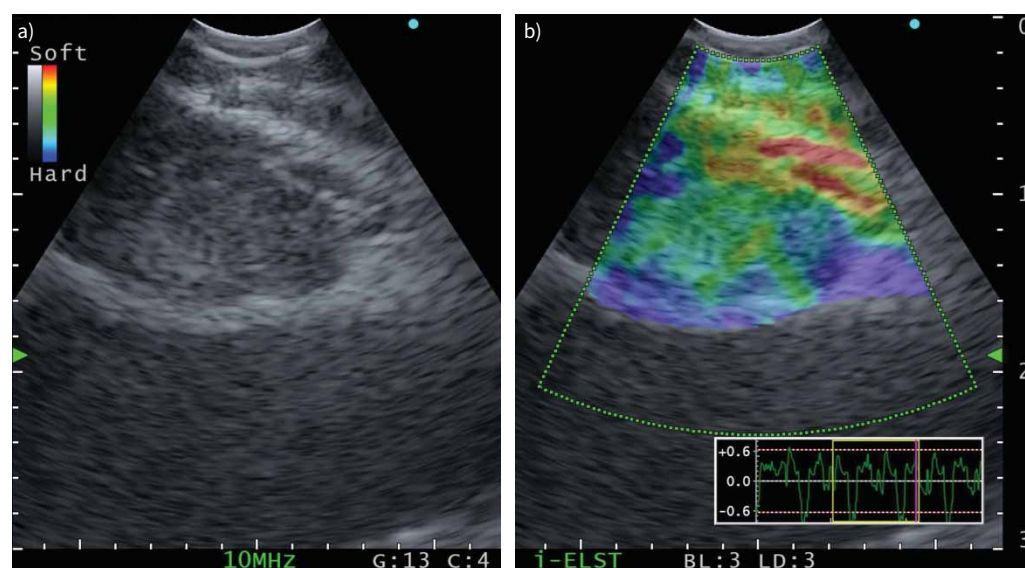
Endobronchial ultrasound (EBUS) examination revealed an oval shaped, distinct lymph node at pre-carinal station 4R (a) with intermediate stiffness on elastography assessment (b).
